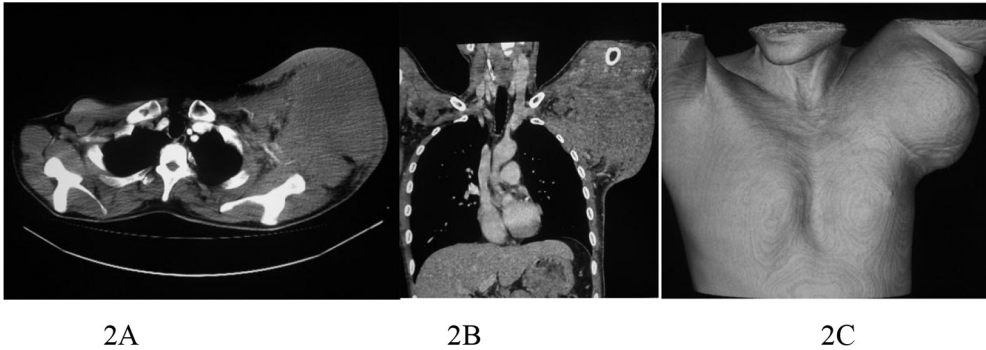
A–C: Thoracic CT scanning with no contrast showed huge lymph node in left armpit in a size of 134 mm × 124 mm as well as necrosis within the node.
